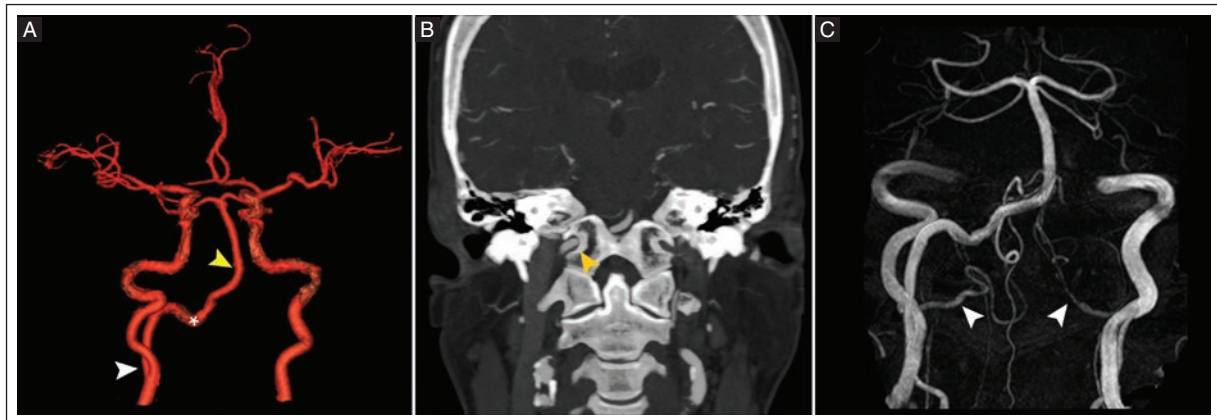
A 55-year-old man with a history of ischemic stroke. A: the 3D CTA shows an anastomosis between the right extracranial ICA (white arrowhead) and the basilar artery (yellow arrowhead) consistent with a PHA (asterisk). B: a coronal CTA shows the PHA passing through the hypoglossal canal (yellow arrowhead). C: 3D-TOF MRA shows hypoplasia of the intracranial segments of both vertebral arteries (white arrowheads).
